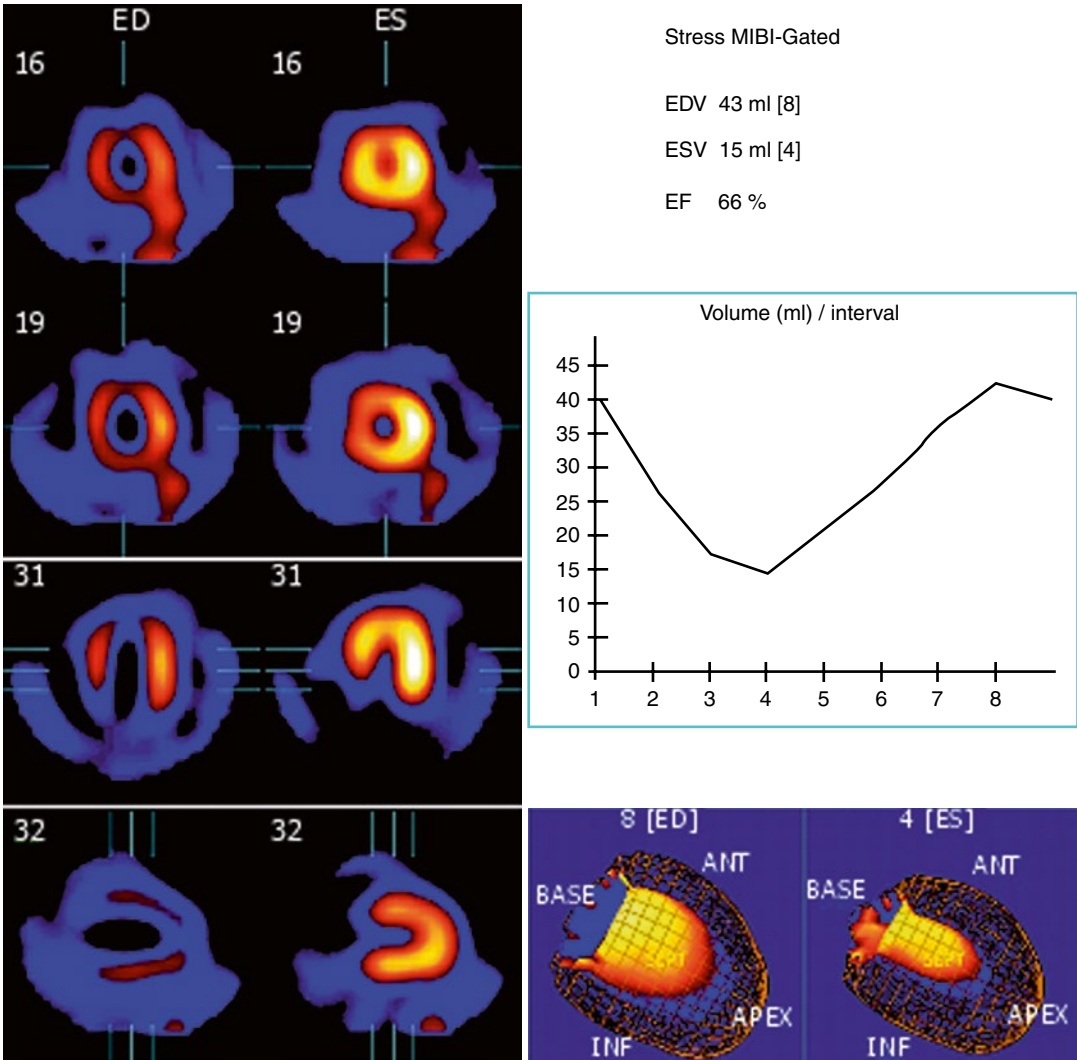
Gated myocardial perfusion SPECT. Selected end-diastolic and end-systolic slices in the short axis and horizontal and vertical long axes are shown. Ventricular
